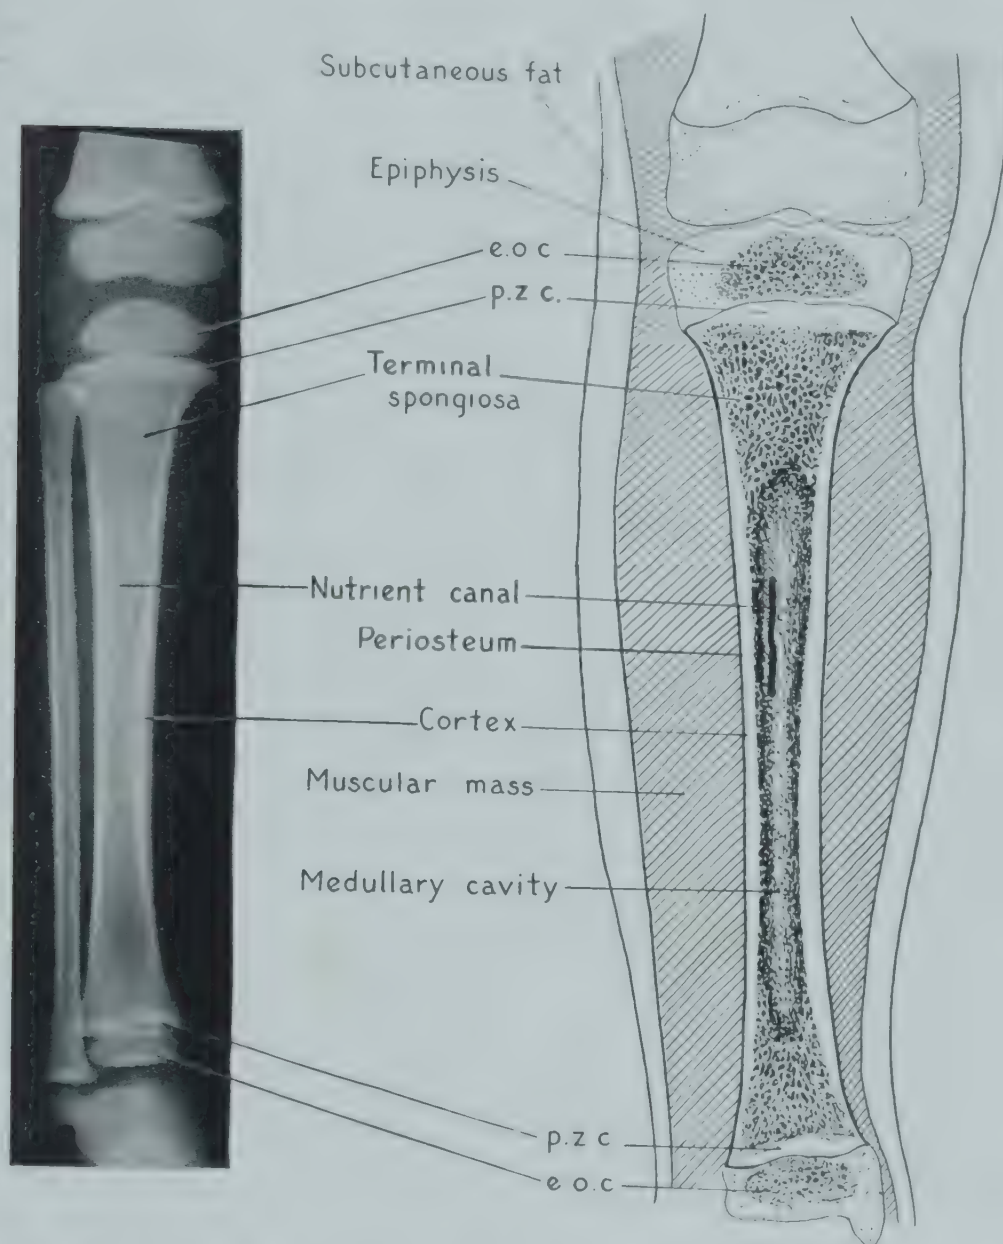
The macroscopic components of a normal tubular bone and their roentgenographic counterparts. A, Roentgenogram; B, longitudinal section of the right tibia of a child 5 years of age; e.o.c., epiphyseal ossification center; p.z.c., provisional zone of calcification. (Adapted from Caffey, J.: *Pediatric X-Ray Diagnosis*, The Year Book Publishers, Inc.)
